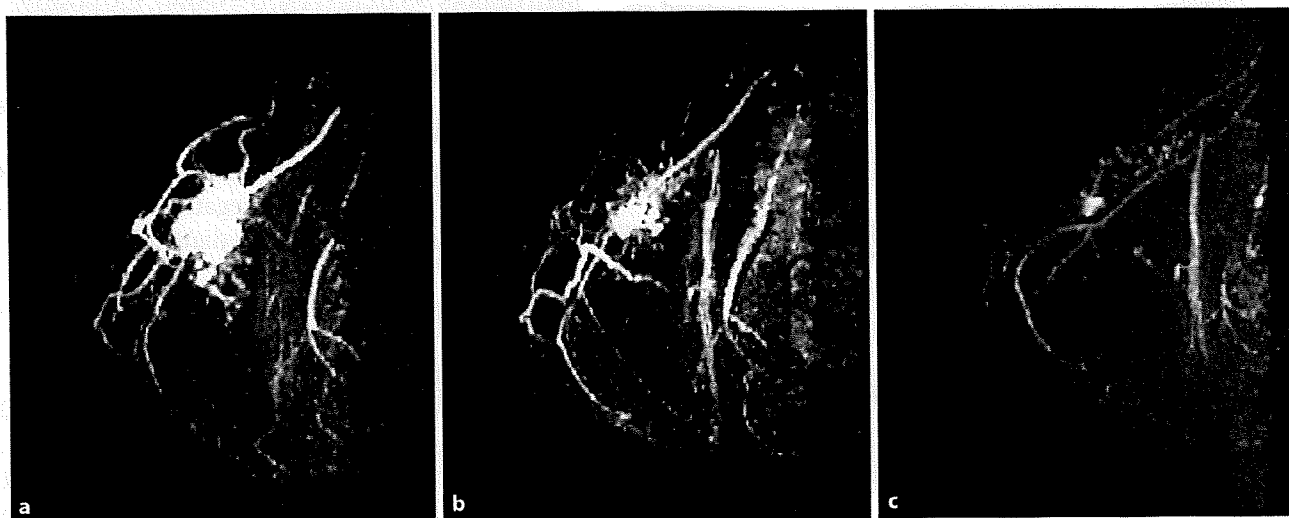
Contrast-enhanced MRI images in a 72-year-old woman with <80% of tumor shrinkage after paclitaxel. a Before paclitaxel. b Reduction rate was 66% after paclitaxel. c The final reduction rate was 93% after the completion of paclitaxel followed by FEC. Her tumor did not attain pCR.
